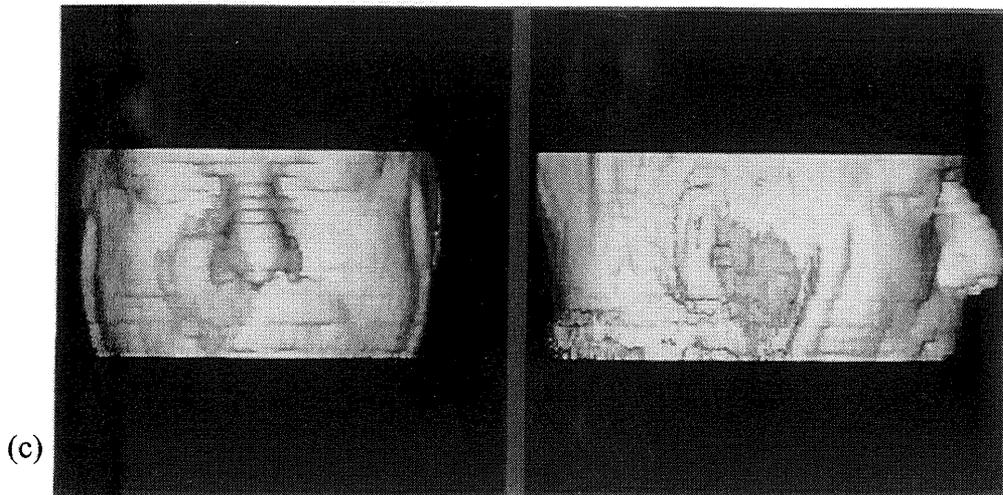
2D and 3D imaging analysis. (a) One cut of CT scan. Notice that the lesion is not shown clearly on CT image. (b) MR angiography of the interested region. (c) 3D profile of the patient's MRI. Lesion was measured as 33cc.
